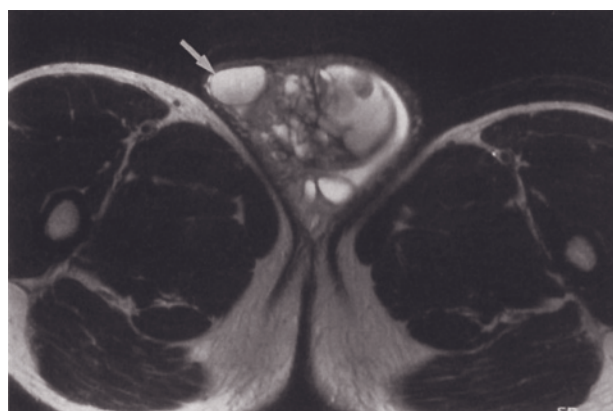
Nonseminomatous testicular neoplasm. T1-weighted gradient-echo (a), T2-weighted ETSE (b), and 45-s transverse (c) and 90-s coronal (d) gadolinium-enhanced T1-weighted gradient-echo images. The left testicle is greatly enlarged, measuring 5 cm in diameter. Tumor replaces the testicle and is mildly heterogeneous on the T1-weighted image (a) and considerably heterogeneous on the T2-weighted image (b). The tumor contains multiple cystic spaces that are well-defined, high-signal-intensity foci (arrow, b) on the T2-weighted image and show lack of enhancement on the postgadolinium images (arrow, c).
